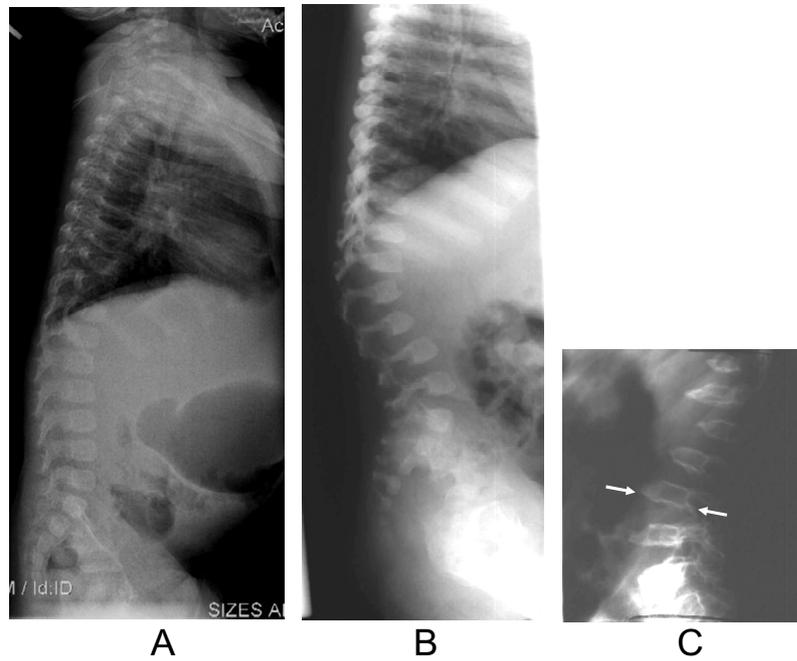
Manifestations of dysostosis multiplex in the spine. Radiographs showing (A) a normal spine, (B) a spine of an MPS patient with several superiorly notched lumbar vertebrae, (C) vertebra showing middle beaking and posterior scalloping (arrows), as well as others which are superiorly notched.
